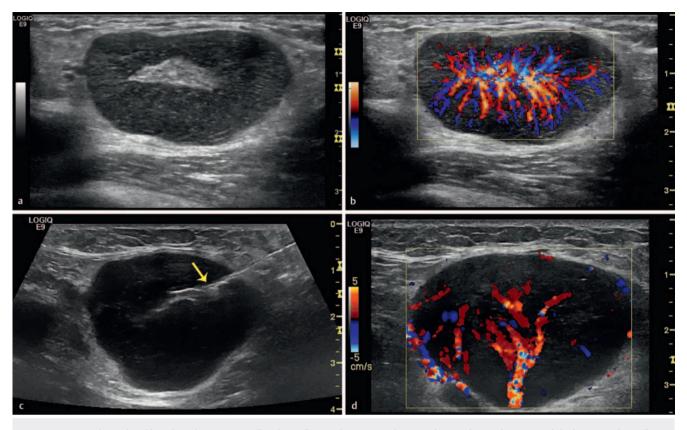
Hypervascularised inguinal melanoma metastasis. Solbiati Index < 2. a B-mode image of the hypoechoic cortex and hypoechoic medulla with central tumour infiltration. b Colour Doppler shows an additional vascular supply via the capsular arteries.
